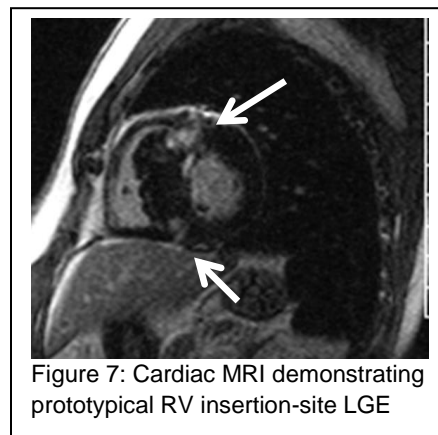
Cardiac MRI demonstrating prototypical RV insertion-site LGE
